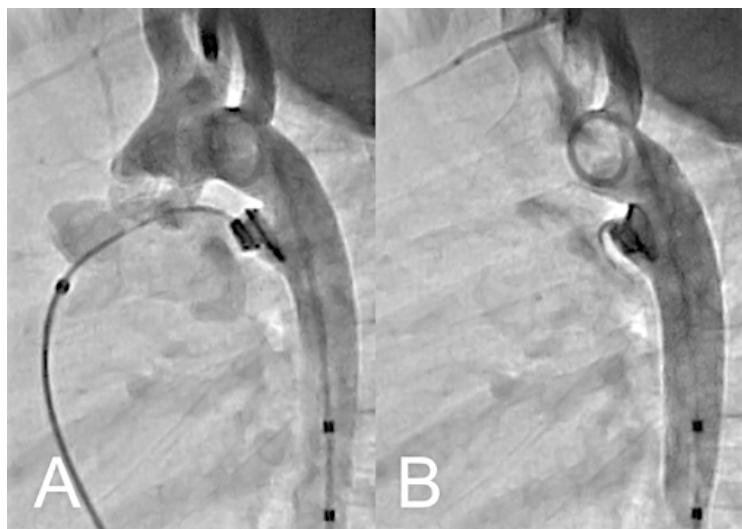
Lateral view of aortogram in the same patient as Figure 1. A 9x6 Nit-Occlud® ductus coil is in the aortic ampulla still attached to the retrieval cable (A). The coil lies slightly angled in the ampulla. In B the coil has been released. The coil has reoriented towards the aorta, but still is not in the true lumen. Approximately 1/2 turn of the coil is within the pulmonary artery. There is a modest amount of residual flow through the ductus that was completely occluded 4 hours later on echocardiography.
